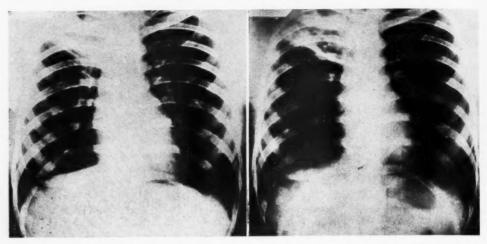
Case 2. Right superior lobe shows irregular opacities, with well-defined interlobular fissure. (Roentgenogram made Aug. 16, 1933.)
